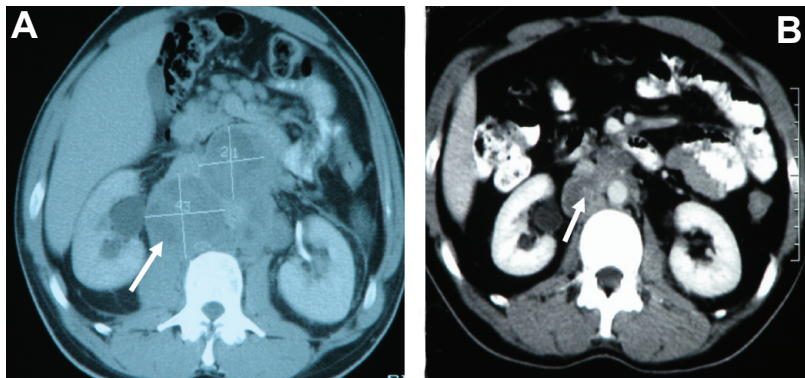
Abdominal CT at the beginning (A) and after (B) of chemotherapy with residual retroperitoneal
